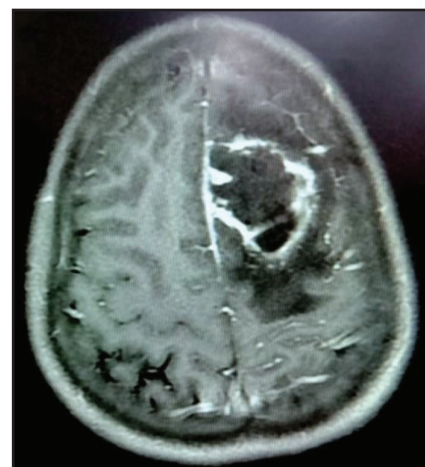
CT image showing an irregular isointense mass in left high frontal lobe involving both grey and white matter.
